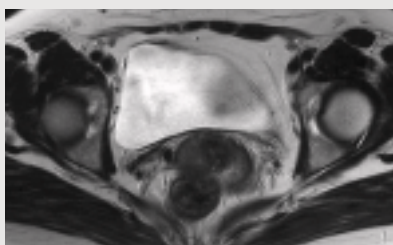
3 T2-weighted images
